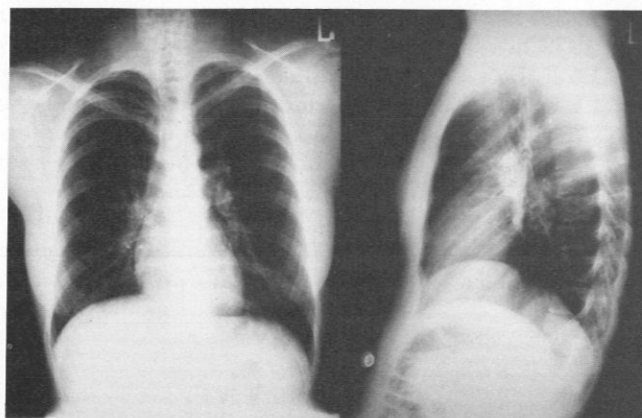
Post-therapy roentgenograms of the postero-anterior and lateral chest show increased volume on the right side and the mediastinum returning towards the left side.
